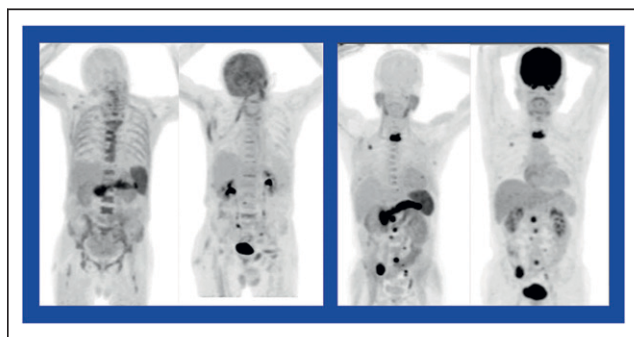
CXCR4-directed endoradiotherapy with  $^{177}\text{Lu}$ - and  $^{99\text{Y}}$ -labeled pentixafer in 2 patients with multiple myeloma. Left 3 images: Before  $^{177}\text{Lu}$ -pentixafer treatment, patient showed sites of CXCR4 expression and uptake on  $^{68}\text{Ga}$ -pentixafer (left), correlating well with uptake on  $^{18}\text{F}$ -FDG (next right), which indicated numerous osseous sites involved. Two weeks after  $^{177}\text{Lu}$ -pentixafer administration  $^{18}\text{F}$ -FDG PET (right) showed a good partial response. Right 3 images: In
